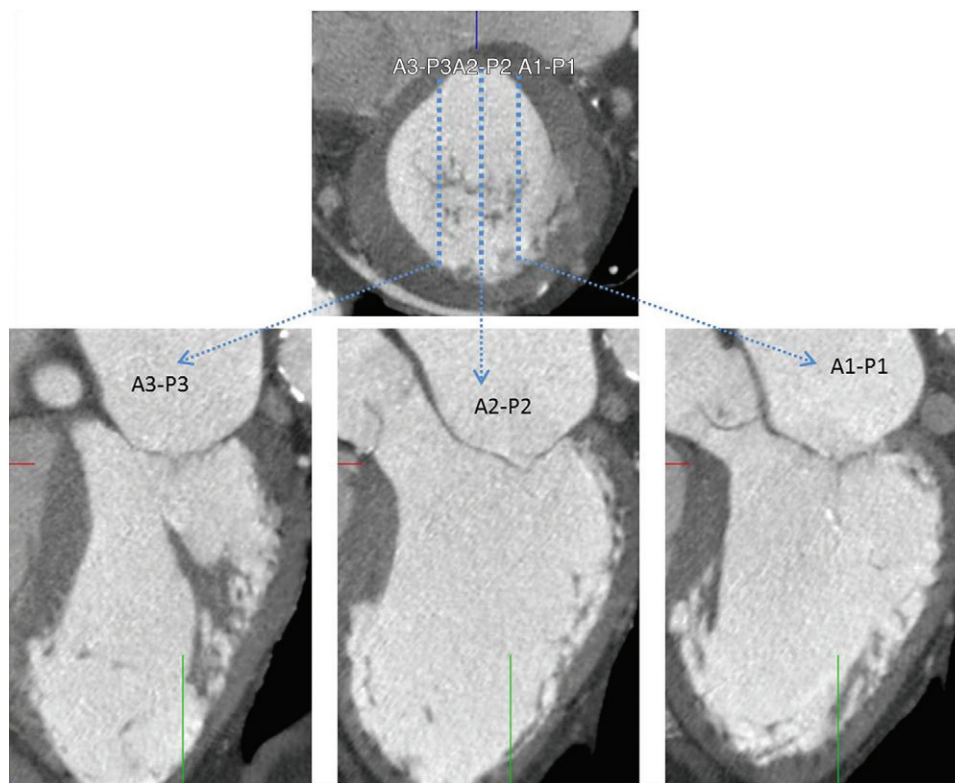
Assessment of mitral valve geometry with CT in a patient with secondary mitral regurgitation. From the reconstructed short-axis view of the mitral valve, the orthogonal plane can be set across the medial (A3–P3), central (A2–P2), and lateral (A1–P1) levels of the mitral valve to obtain the length, tenting height, and leaflet angles of the anterior and posterior mitral leaflets.
